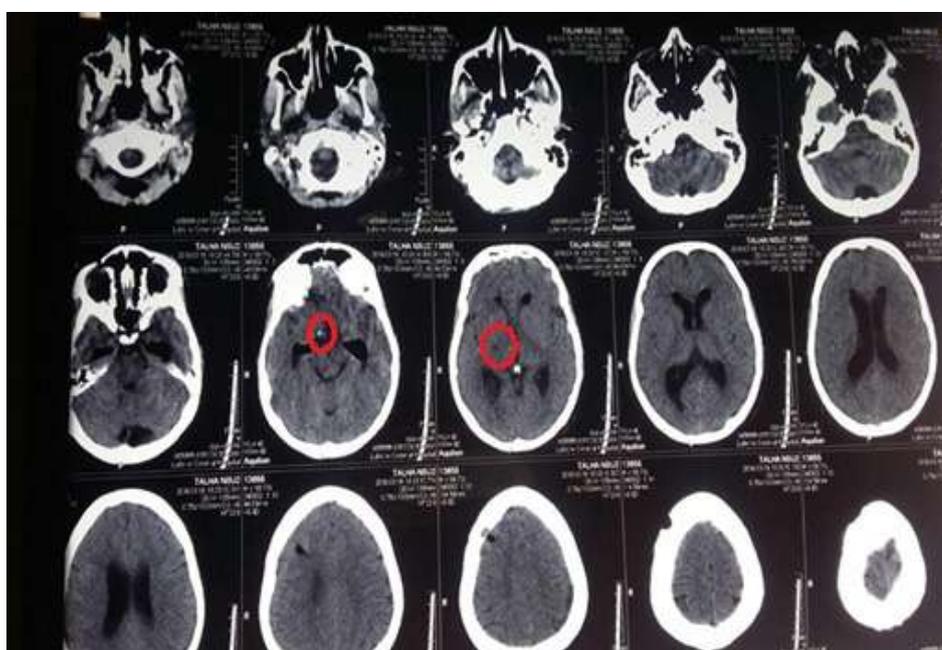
Postoperative CT scan following pallidotomy demonstrating the stereotactic lesion within the globus pallidus internus (encircled red), obtained to confirm target placement and exclude postoperative complications.
